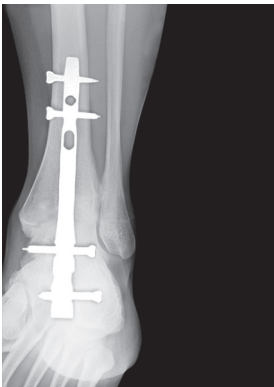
X-ray: Ankle arthrodesis with PFN
